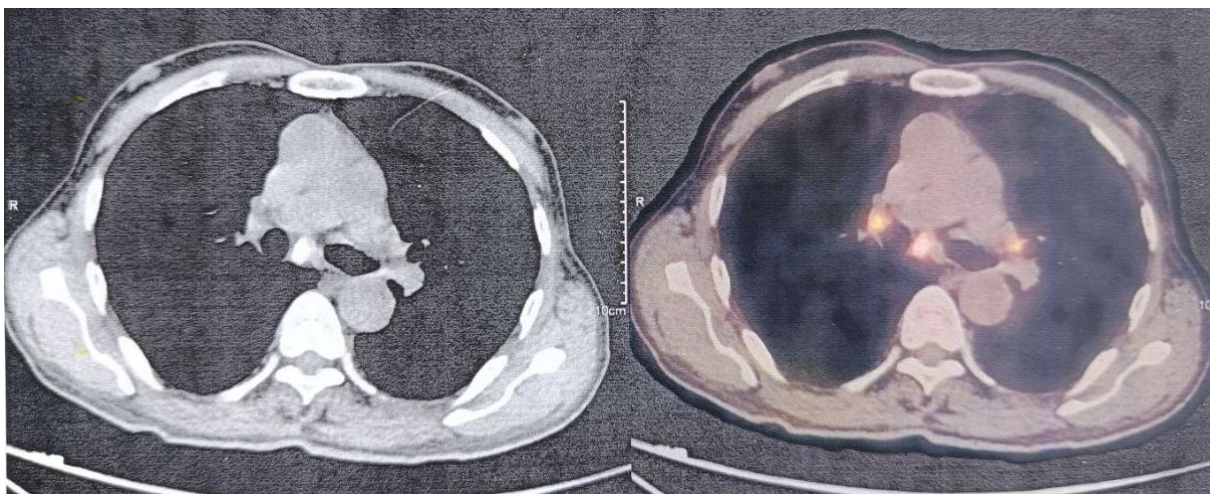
Shows Mediastinal Lymph Nodal Enlargement Seen on Ct Image on left which is FDG Avid as seen in the Image on Right.
